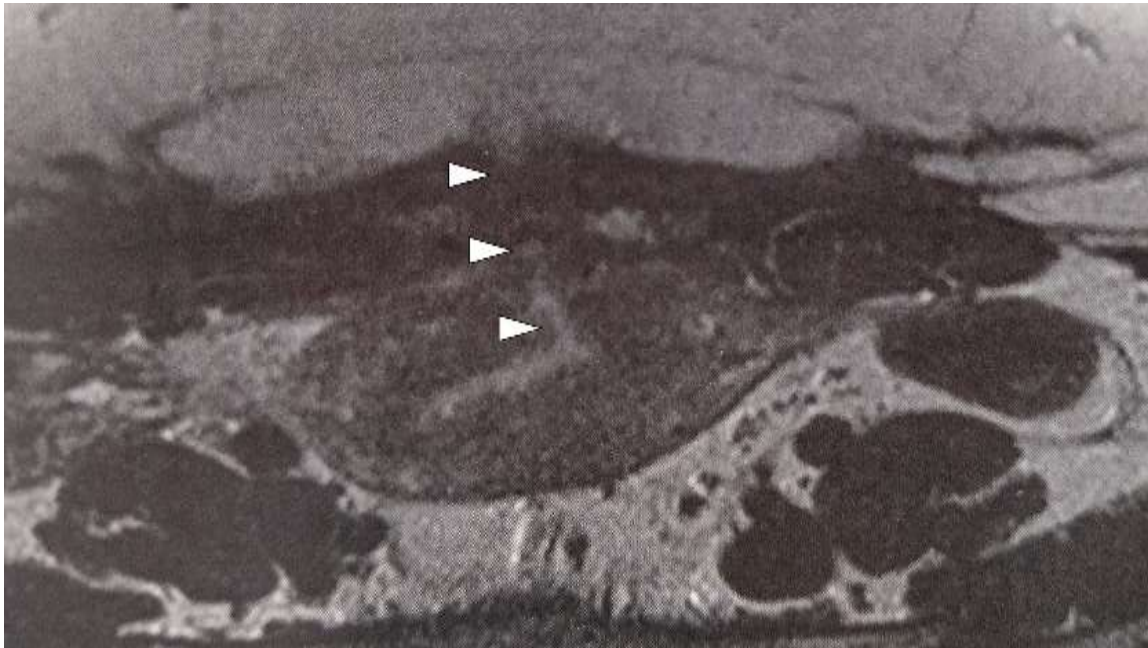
Pelvic MRI : Axial T2-weighted shows a tubular, T2-hyperintense fistulous tract (arrowheads) arising from the anterior uterine wall/cesarean scar region and coursing anteriorly through the preperitoneal and abdominal wall soft tissues toward the skin, consistent with a uterocutaneous fistula.
